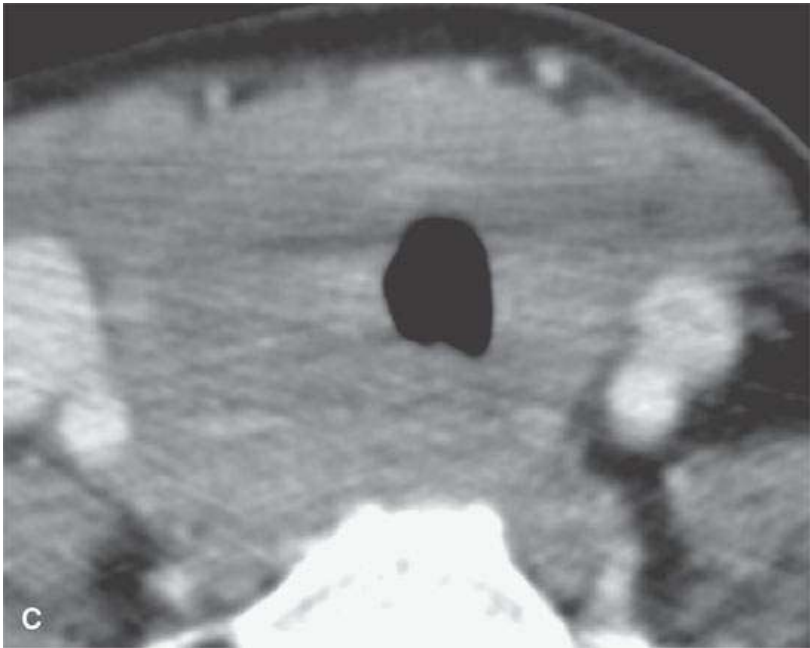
Contrast-enhanced computed tomography studies of four patients with thyroid lymphoma of various degrees of involvement of the gland and surrounding structures. A;; Bilateral symmetric gland enlargement essentially indistinguishable from other causes of generalized glandular hyperplasia. B: Unilateral enlargement with early spread beyond the gland capsule in a pattern that would also suggest anaplastic carcinoma. C : Diffuse enlargement with extensive spread beyond the gland capsule in a pattern that would also suggest anaplastic carcinoma. D, E: The potential for airway compromise (D) and compromise of adjacent nerves manifest here as true vocal cord weakness (E).
